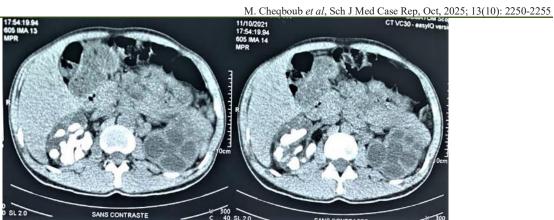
Transverse abdominal CT scan: bilateral renal dilation with large staghorn calculus on the right and cortical thinning
